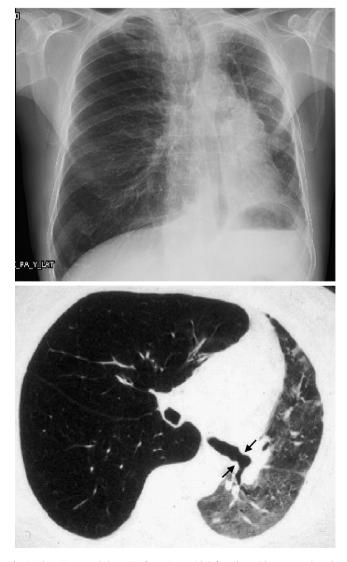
Chest X-ray and chest CT of a patient with left unilateral lung transplant due to COPD.
